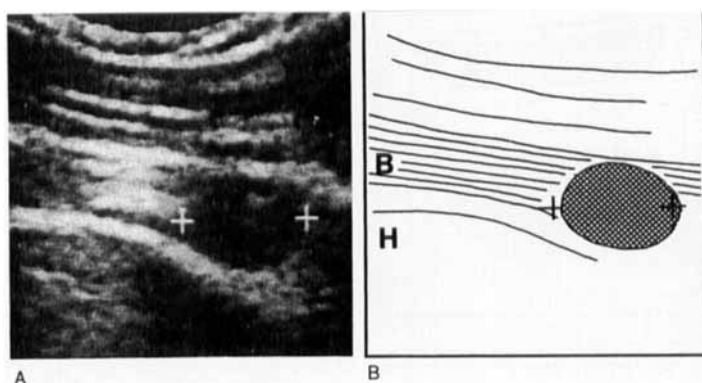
A and B. Longitudinal sonogram showing hyperechoic biceps tendon (B) containing a circular echo-poor area (hatched area between crosses) representing a hematoma. H = humerus.
